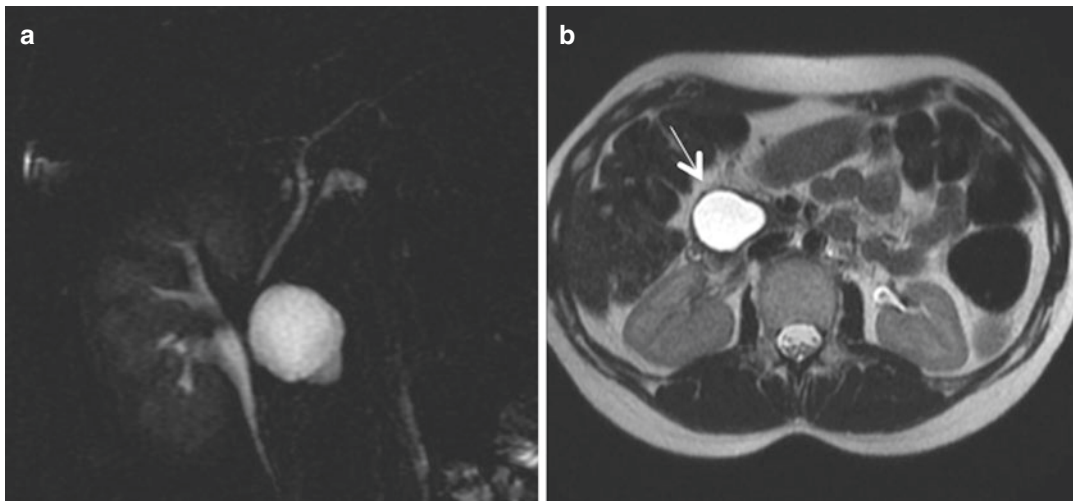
Mucinous cystadenoma in the head of the pancreas that appears on (a) 2D-MRCP image and on (b) axial T2-weighted image as unilocular hyperintense fluid lesion (arrow) with no communication with the MPD
